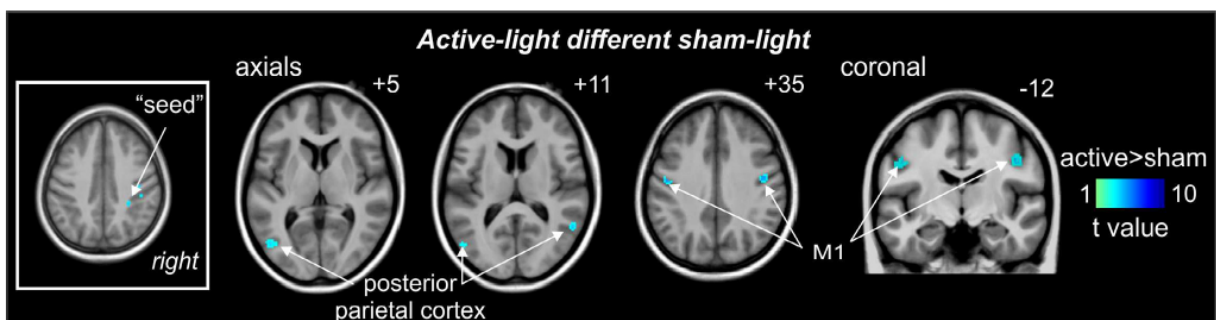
Effects of active- and sham-light on resting parietal association cortex functional connectivity. Significant differences in right parietal association cortex resting connectivity strengths before and after active compared with sham-light. Region in which resting connectivity was significant reduced by active-light more than sham-light are indicated by the cool colour shading and overlaid onto a series of axial and coronal T1-weighted anatomical images. Slice locations in Montreal Neurological institute space are indicated at the top right of each image. Note that active-light significantly reduces resting connectivity strength between the right parietal association cortex and the left and right posterior parietal cortex as well as the left and right primary motor cortex (M1).
